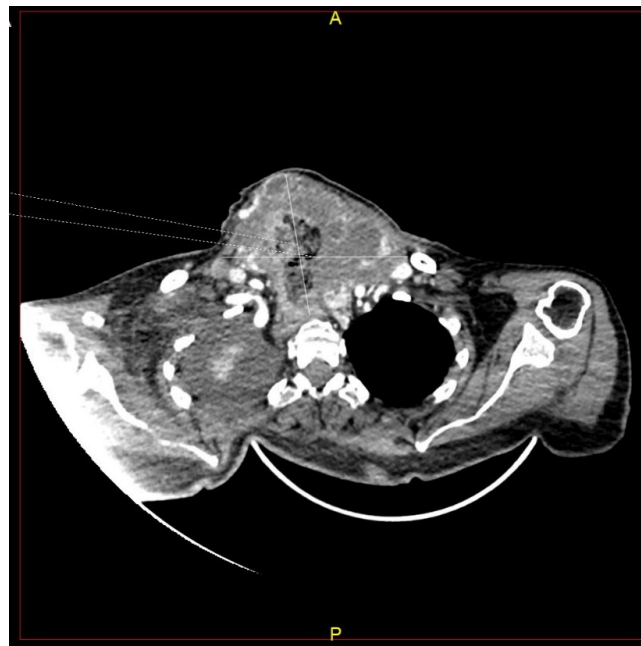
Contrast-enhanced computed tomography image of the neck and thorax revealing a necrotic tumor mass in the neck and atelectasis of the left lung.
